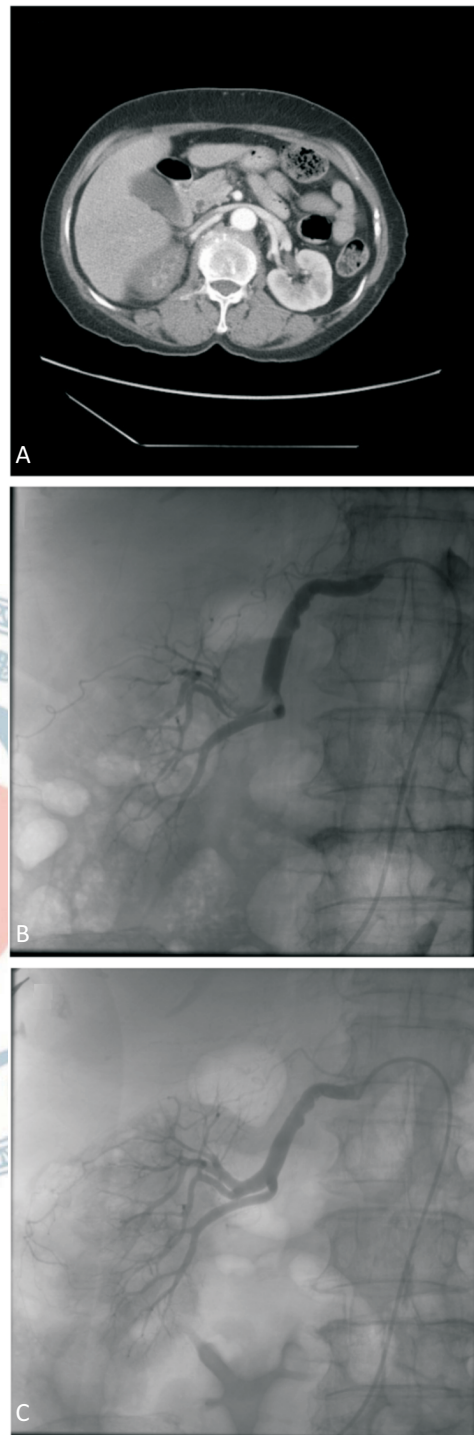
Representative images of one patient. A 72-year-old female presented to our emergent department with acute right flank pain. (A) The contrast-enhanced computed tomography disclosed a small enhanced area of the right kidney compared to the normally perfused left kidney, suggesting right renal artery occlusion. (B) Selective right renal angiogram showed a filling defect at the distal right renal artery. (C) Renal angiogram, repeated after 24 hours of continuous local infusion of urokinase, showed complete resolution of thrombosis.
